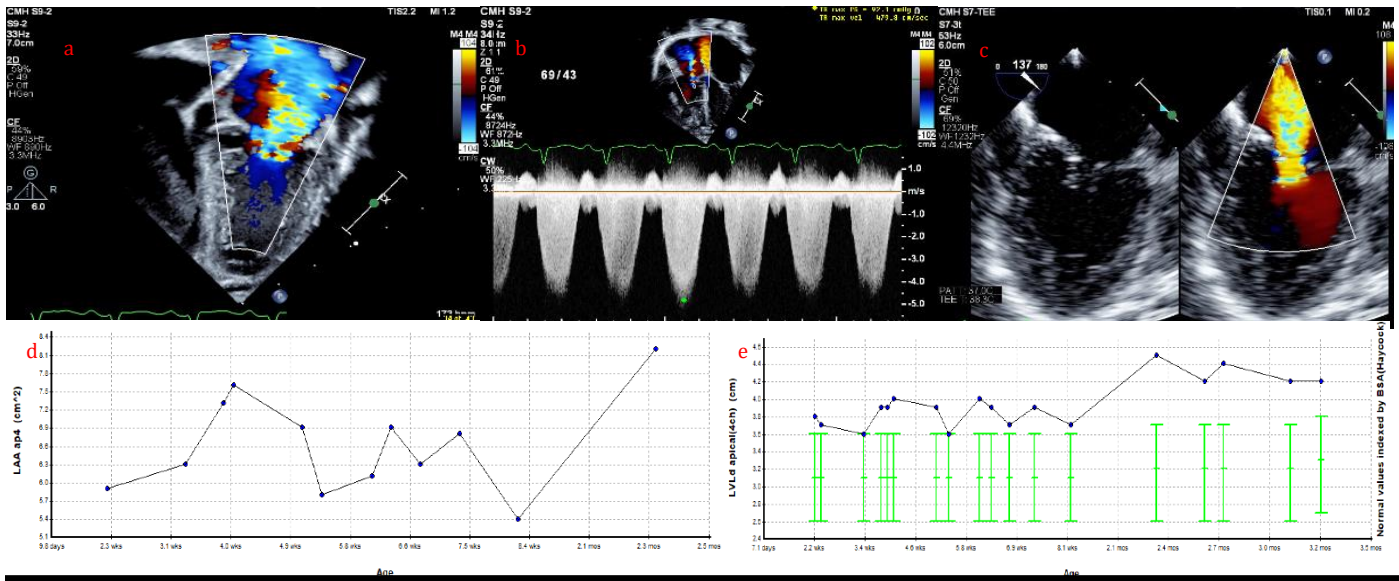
Echocardiographic imaging and graphic trends
